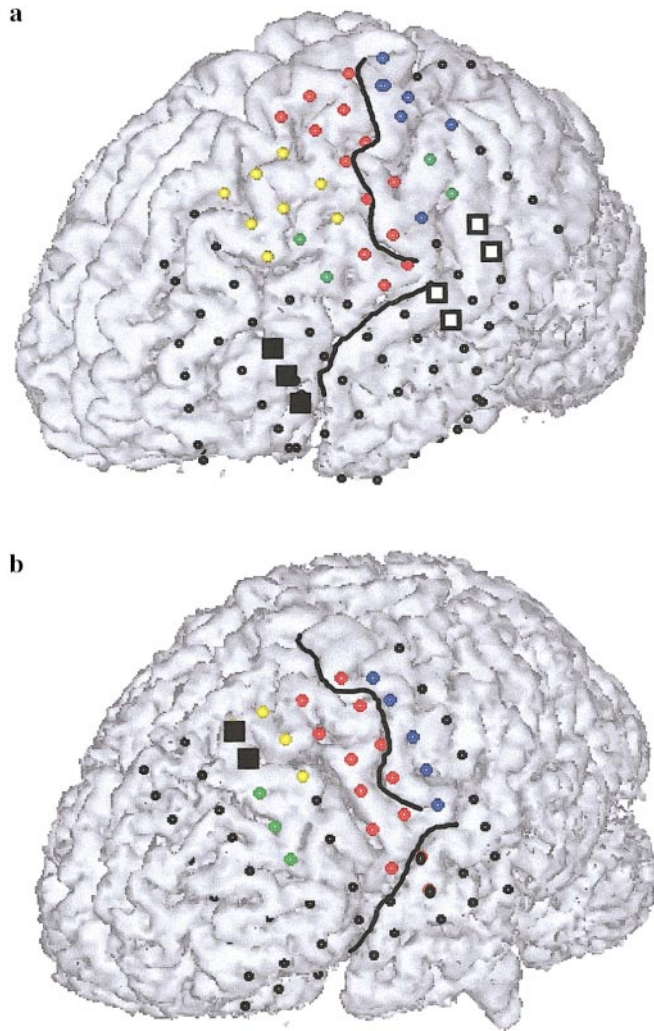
Anatomical location of frontal electrodes. The three-dimensional MR images with the implanted electrodes are shown for patient A.M. (a) and patient D.K. (b) The behavioral responses as found by stimulation mapping are indicated as follows. Complex visual hallucination at frontal electrodes: black square; eye movements: yellow; other motor responses: red; somatosensory responses: blue; language responses: green. Black circles localized over the frontal cortex represent sites at which no overt responses were evoked. The central sulcus and the lateral sulcus are outlined (black lines). The letters refer to positions of stimulated electrodes on the grid. Each row is numbered from 1 to 8 (down to top, i.e., language responses evoked in patient A.M. over the frontal lobe at electrodes D5 and D6).
